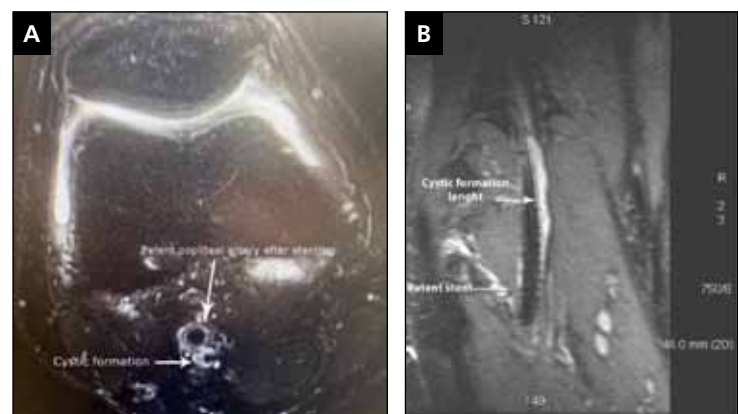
MRI of the right popliteal artery showing a cystic formation on the back artery wall with patent stent and no sign of compression. (A) Transversal view. (B) Sagittal view.
